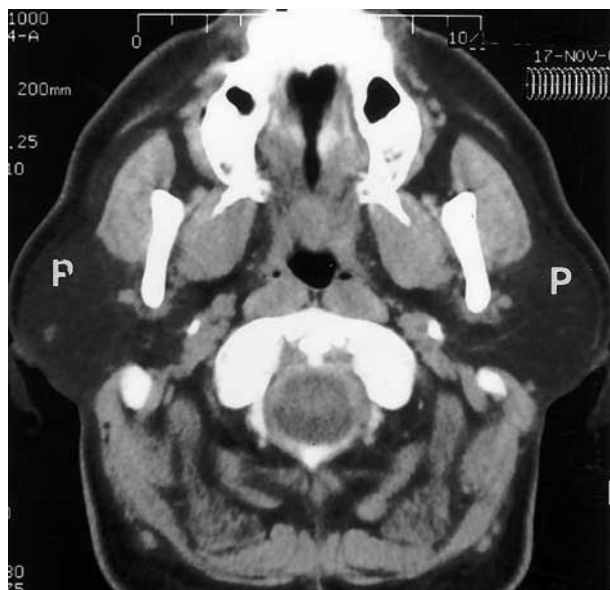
Computed tomography scan showing bilaterally enlarged low-density parotid glands (P), reflecting a fatty infiltration.
